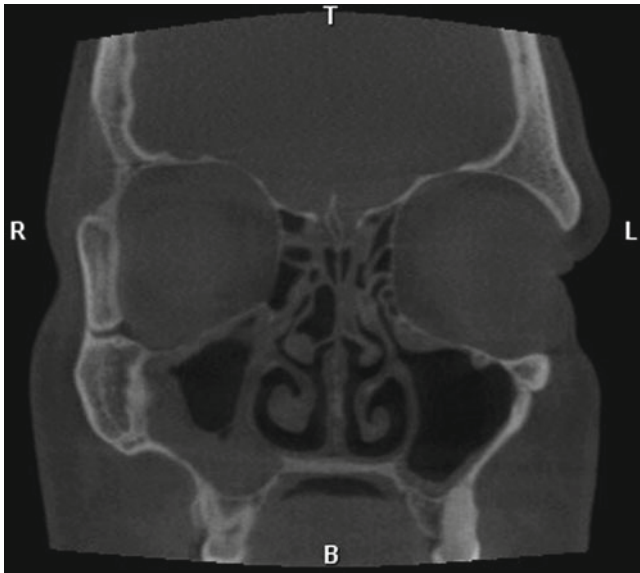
CT of the sinuses
